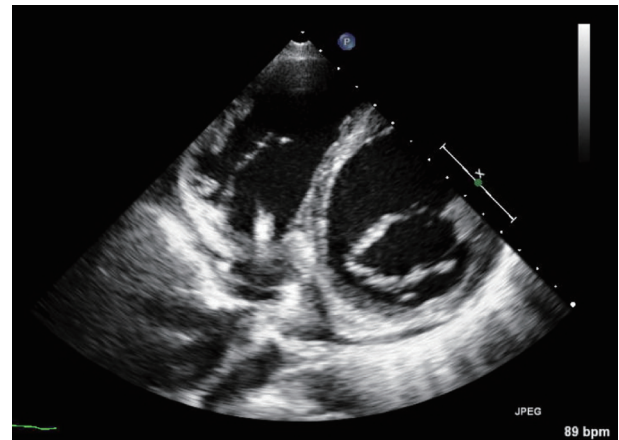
Parasternal short-axis mitral valve unconventional view displaying *de novo* fibrin-sheath involving the electrocatheter with an additional punctiform image.
